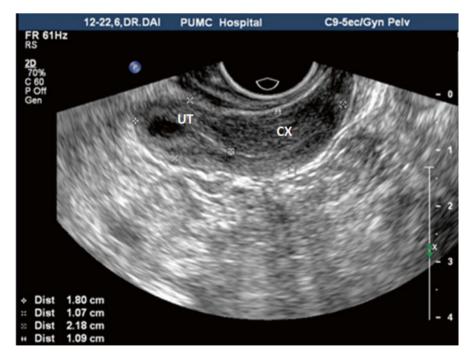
Transvaginal ultrasound showing an infantile uterus. A 24-year-old patient presenting primary amenorrhea. All the uterine diameters are significantly smaller than normal with uterine body size: $1.8 \times 1.5 \times 1.1$ cm, cervical length 2.2 cm, and body/cervix ratio <1
